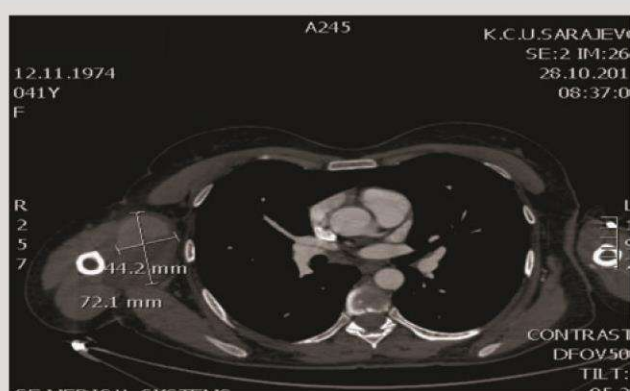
CTA (axial view).
